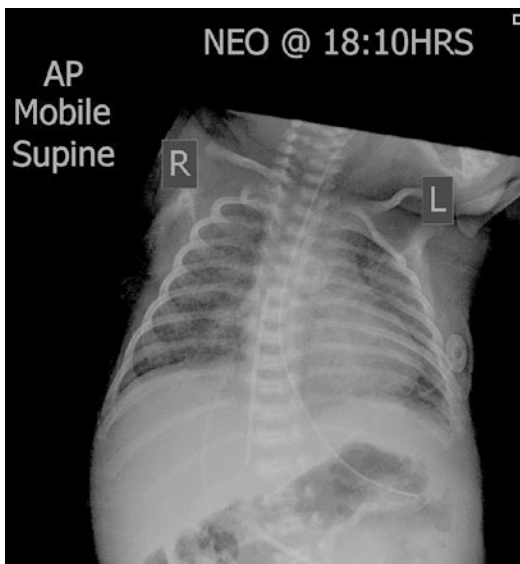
Radiograph showing distal catheter embolus with the retained fragment free-floating in the right heart chambers following an unsuccessful attempt at removal. Such procedures should not be left to the surgical novice. This line was subsequently successfully snared and removed transfemorally in the cardiac catheter suite
